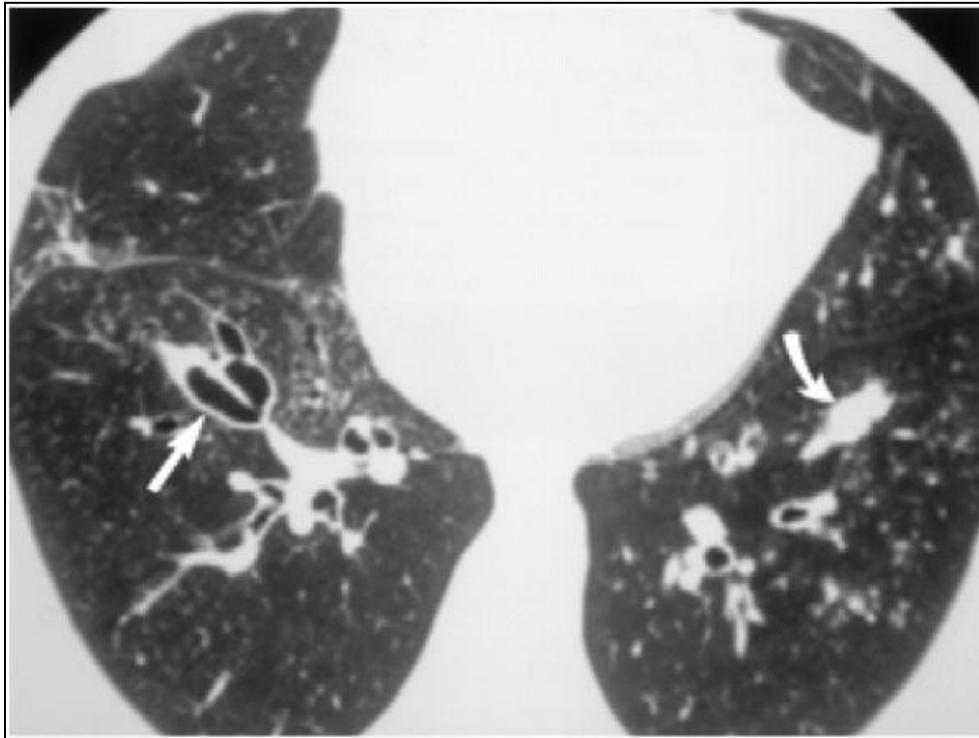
Allergic bronchopulmonary aspergillosis. Axial high resolution CT image reveals central bronchiectasis (straight arrow) and mucoid impaction (curved arrow), characteristic of allergic bronchopulmonary aspergillosis [4].
